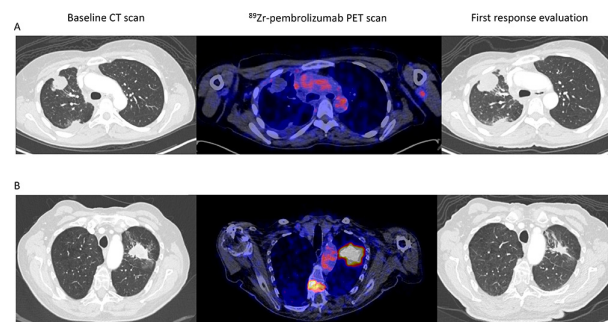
Two examples of [^{89}Zr]Zr-pembrolizumab tumor uptake (scaled 0–8) in patients with metastatic NSCLC and a CT scan before and during PD-1 antibody treatment. (A) On the left, an axial view of the baseline CT scan. In the middle, the [^{89}Zr]Zr-pembrolizumab PET/CT scan before starting treatment shows no uptake in tumor lesions in right lung. On the right, the first CT scan made 40 days on treatment, demonstrating progressive disease. (B) On the left, an axial view of the baseline CT scan before treatment. In the middle, the [^{89}Zr]Zr-pembrolizumab PET/CT scan before starting treatment shows clear uptake in the lung lesion and in a bone metastasis in the spine. On the right, CT scan made 44 days on treatment demonstrating a partial response. NSCLC, non-small-cell lung cancer; PET, positron emission tomography.
